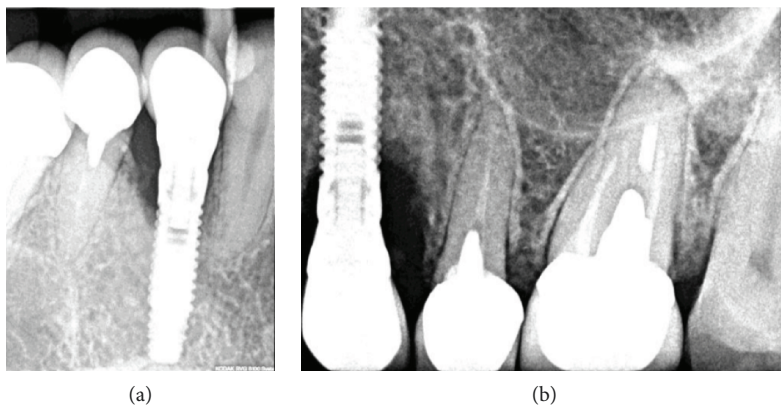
(a, b) Radiographic examination with different positions of the holder.
